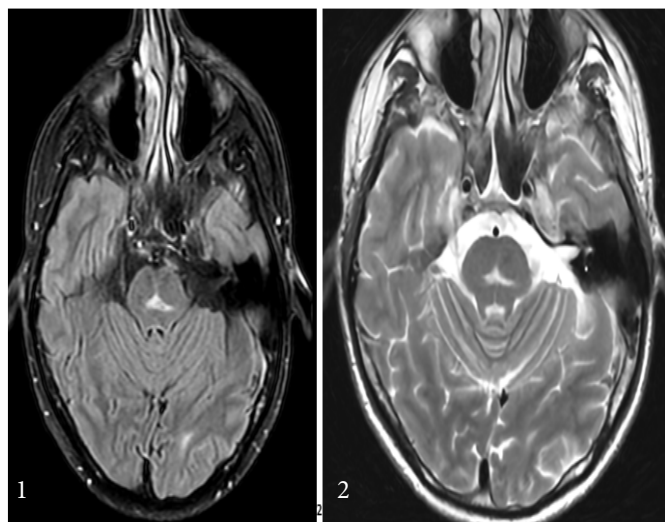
Axial T2-weighted MRI images of the brain showed a hyperintense lesion in the midline of the pons
